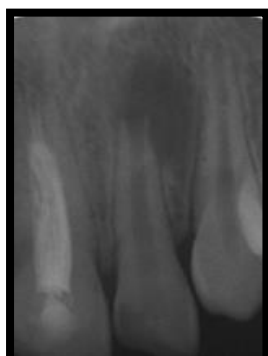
Preoperative radiograph: an open apex & periapical radiolucency
